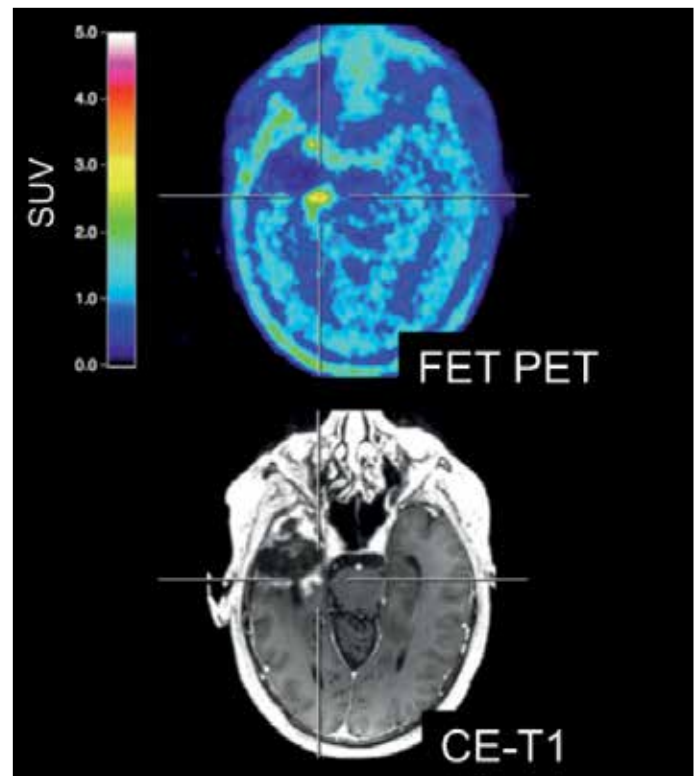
FET and MRI images of glioma
